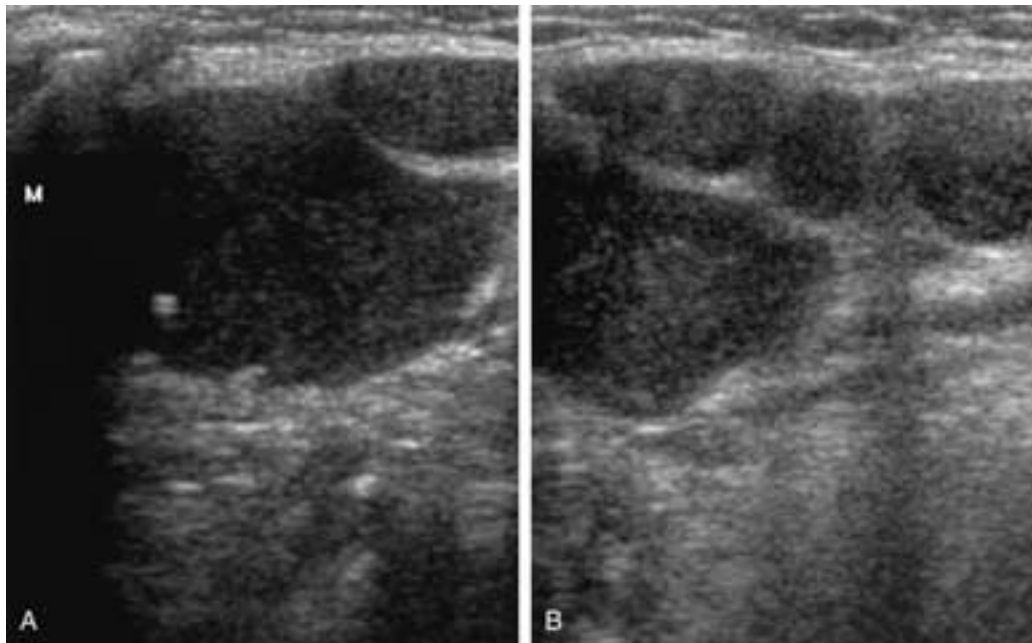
A and B, Plunging ranula. Coronal ultrasound demonstrates a multilobular cystic lesion in the submandibular space adjacent to the mandible (M) but extending beyond the mylohyoid muscle. The cysts are well defined and are not truly anechoic due to their high protein content.
